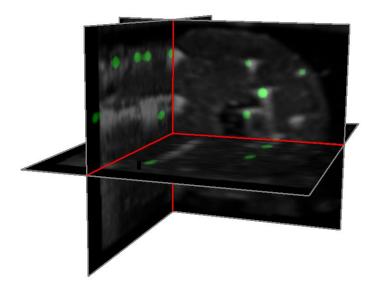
Overlay view of US volume and binarized CT volume. The green spots show the implanted seeds segmented from the CT data.
